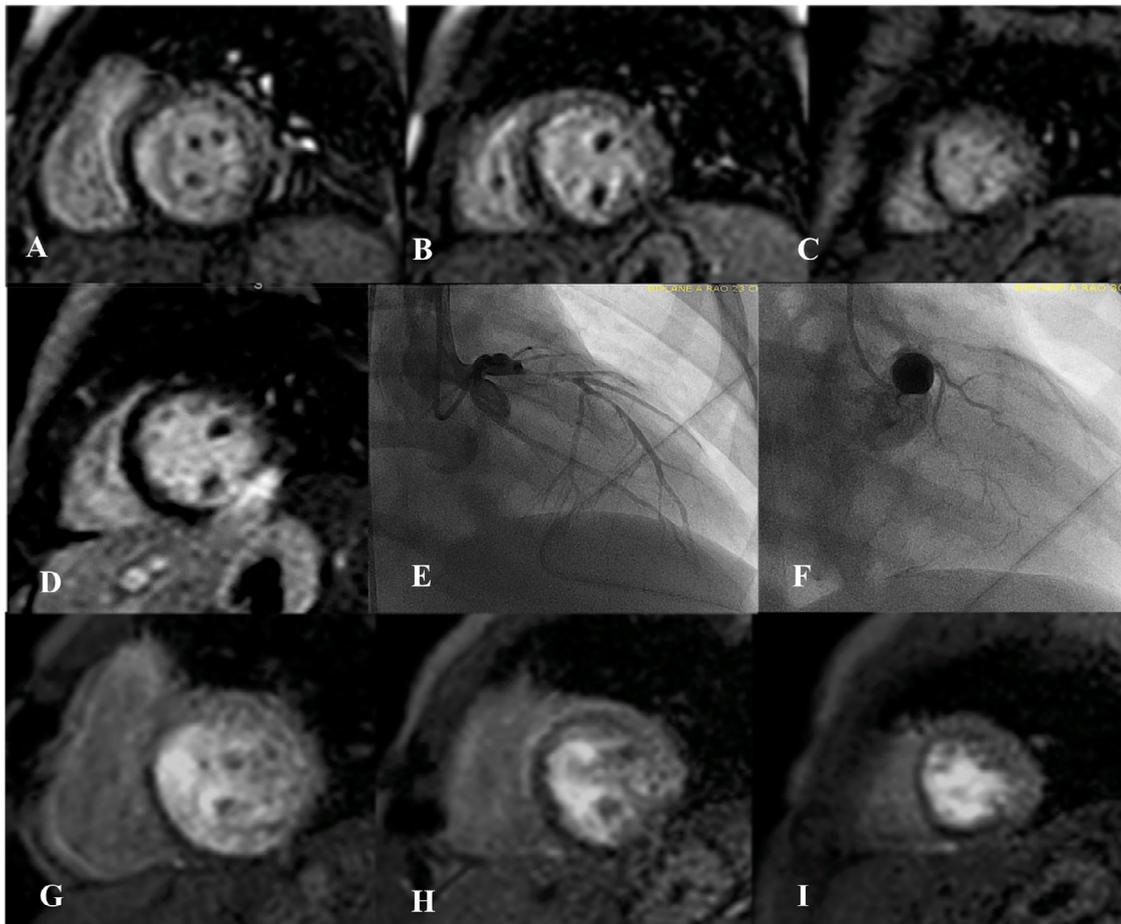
Stress CMR and XRCA in a 2-year-old patient (13 kg) with right dominant CA. Hypoperfusion (Supplementary Video 3) was seen in the anteroseptal, inferoseptal, and inferior segments of the basal (A) and mid-ventricular (B) region as well as the septal and inferior apical segments (C). Small transmural LGE was apparent in the inferior wall (D). XRCA demonstrated moderate left CA aneurysm with severe LAD stenosis (E, Supplementary Video 1), and giant RCA aneurysm with severe stenosis with reconstituted collateral formation (F, Supplementary Video 2). A follow-up regadenoson stress perfusion CMR 20 months after LIMA-LAD graft showed hypoperfusion in the endocardial region of the anterior septum and small hypoperfusion in the inferior septum (G to I, Supplementary Video 4). CA = coronary artery; CMR = cardiac magnetic resonance imaging; LAD = left anterior descending coronary artery; LGE = late gadolinium enhancement; LIMA = left internal mammary artery; RCA = right coronary artery; XRCA = X-ray coronary angiography.
